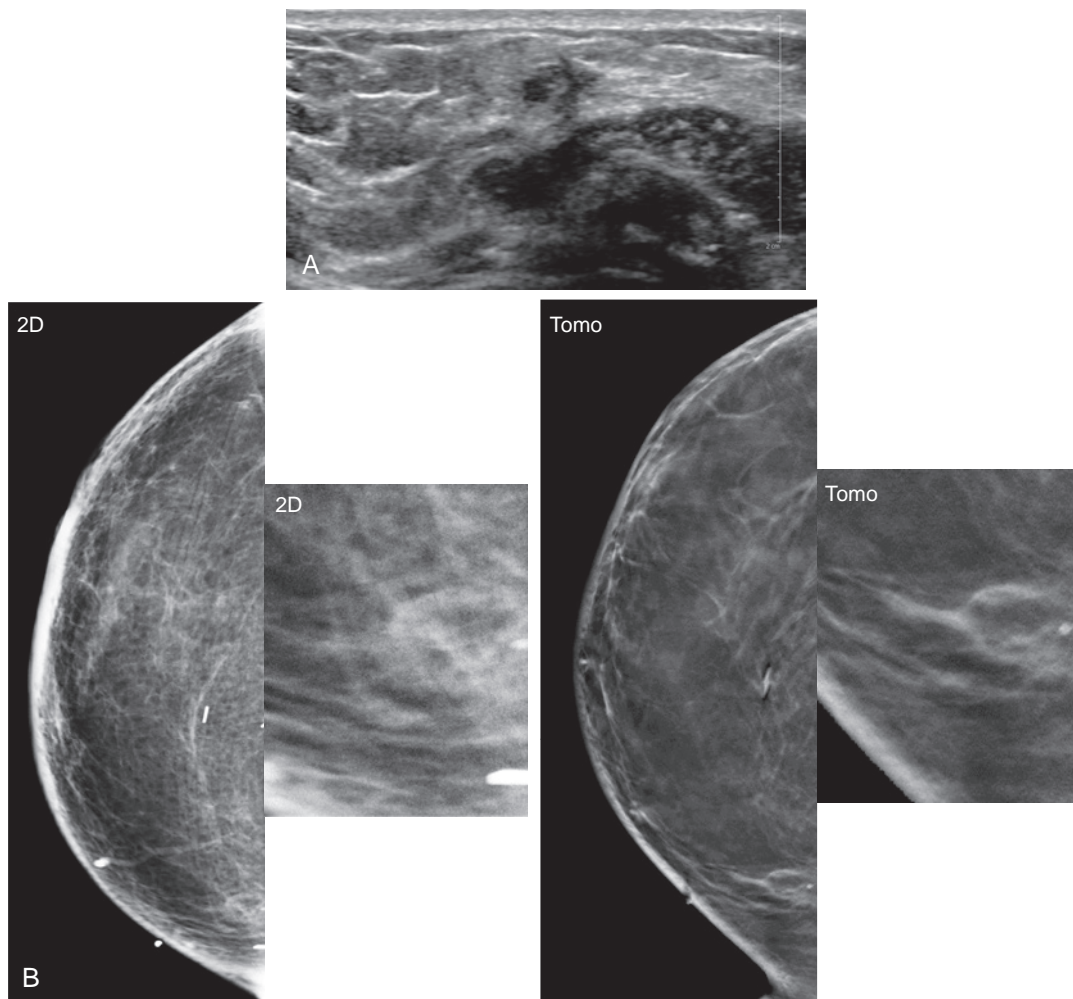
Palpable fat necrosis (A) A 42-year-old woman with history of right mastectomy and deep inferior epigastric artery perforator flap reconstruction presents with palpable mass in medial reconstructed breast. Targeted ultrasound demonstrates a corresponding irregular mixed echogenic mass with indistinct margins. (B) Because the ultrasound findings were inconclusive, mammography was performed. 2D images reveal predominately fatty tissue and an asymmetry in the region of palpable concern, whereas tomosynthesis confirms the presence of a lucent mass consistent with fat necrosis, BI-RADS 2.
